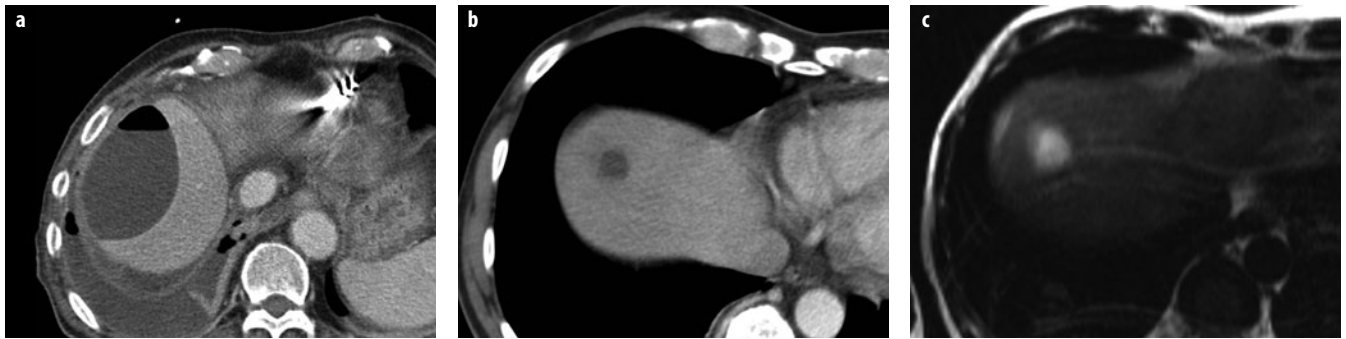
a-c. Abscesses. a Typical large subcapsular abscess with an air-fluid level and a reactive pleural effusion. b. In another patient, computed tomography (CT) shows a small, thick-walled abscess after pancreatic surgery. c T2-weighted MR image of the same patient shows the thick, indistinct wall and peripheral edema
